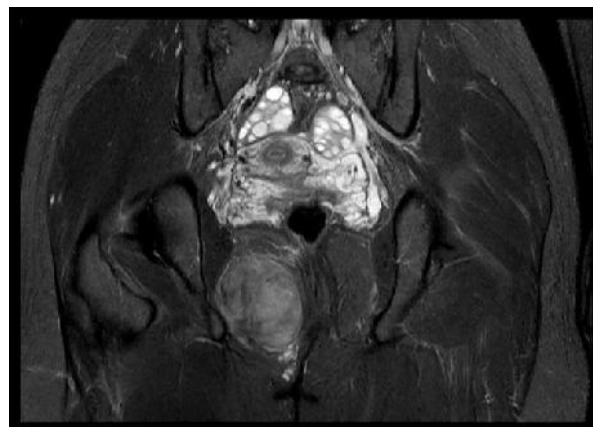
Magnetic resonance imaging of lesion
